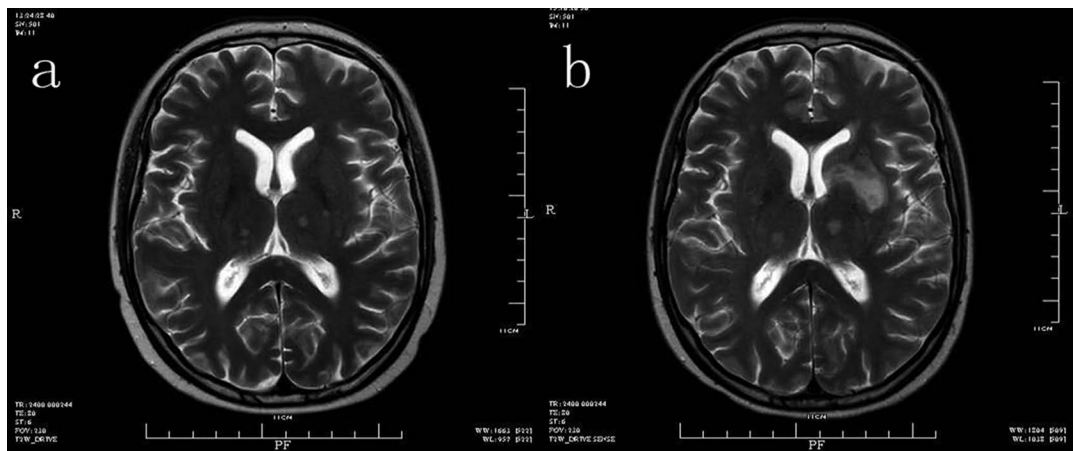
MRI scan of the brain revealed multiple hyperintense metastatic lesions on T2WI (a); the metastatic lesions were significantly enlarged after 24 weeks of treatment with ceritinib (b).
